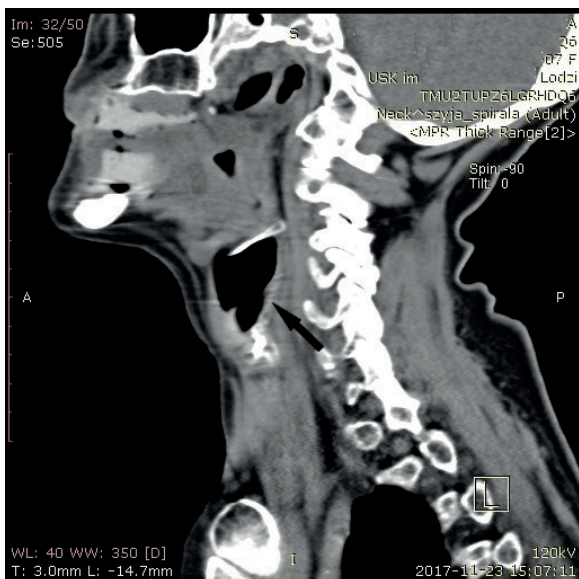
CT sagittal view: visible laryngocele
